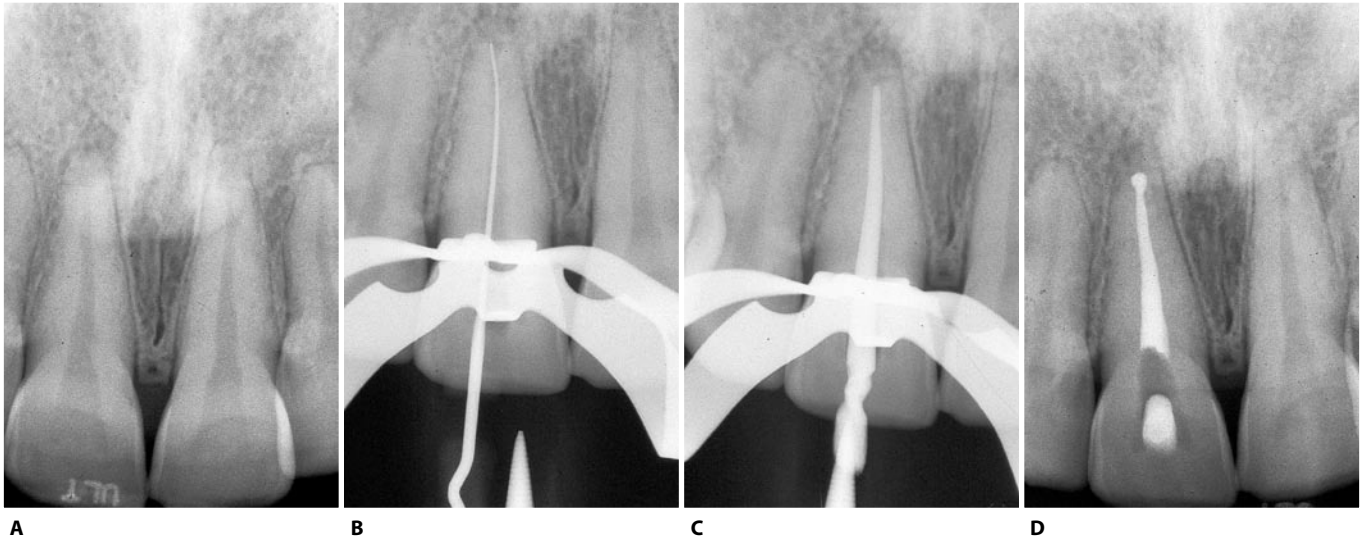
A. Preoperative radiograph of the upper right central incisor with necrotic pulp. B. The apex locator indicated that the instrument is at the apex, but the radiograph shows that it is short. In these cases the locator is always correct! The foramen is buccal or palatal and cannot be identified radiographically. These cases then are treated up to the electronic apex. C. Cone fit. D. Post operative radiograph. The small enlargement visible at the extremity of the obturating material is nothing more than the classic puff of sealer extruded from the apex. Note its position with respect to the radiographic apex.
